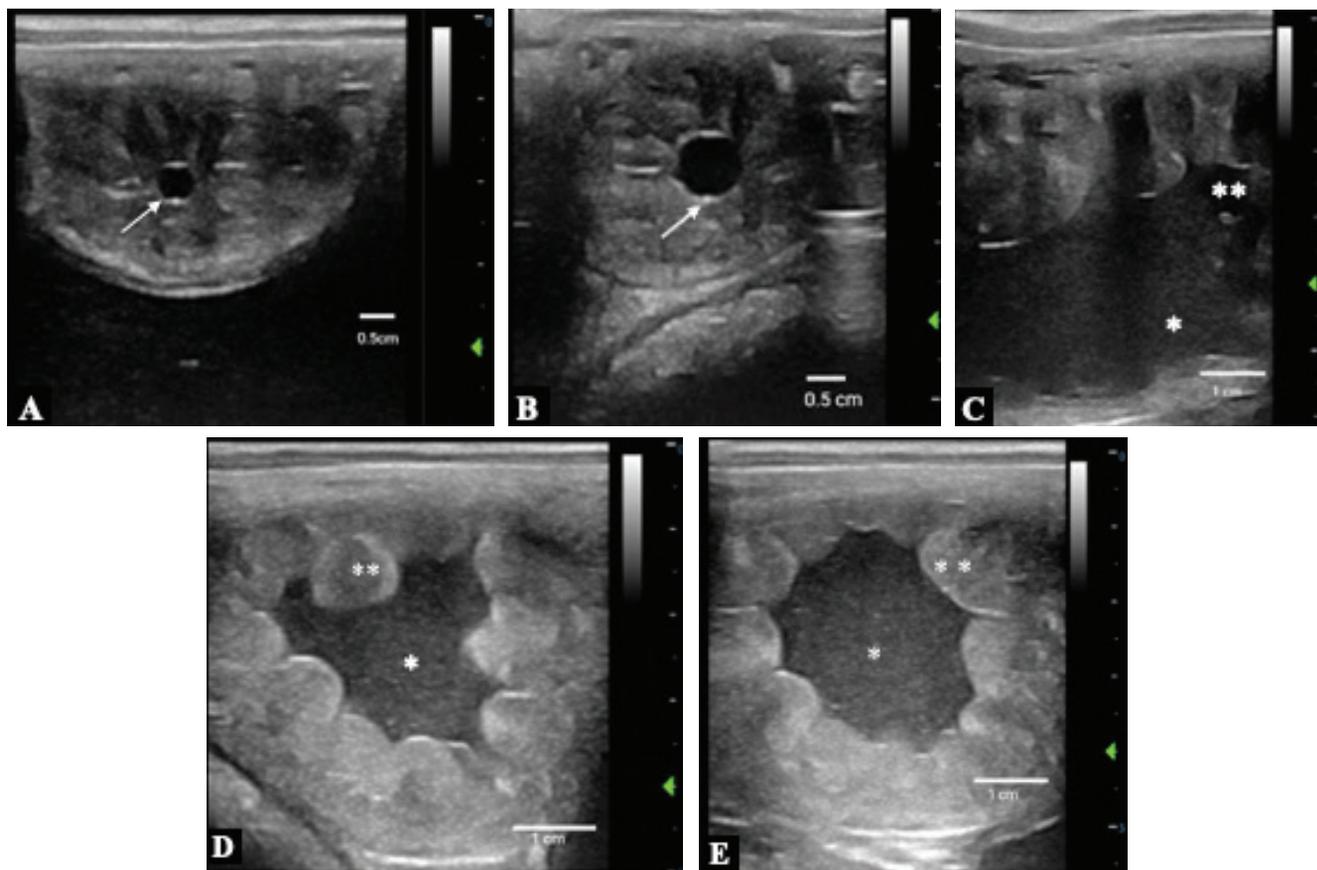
Transrectal ultrasonographic images of uterus: A. Day 10 embryonic vesicle (white arrow) of 0.4 cm and grade 1 endometrial edema; B. Day 11 embryonic vesicle (white arrow) of 0.8 cm and grade 2 endometrial edema; C. Day 12 embryonic vesicle; D and E. Days 13 and 14 embryonic vesicle (note hyperechoic free fluid visible in the uterine lumen* and uterine mucosa edema)
